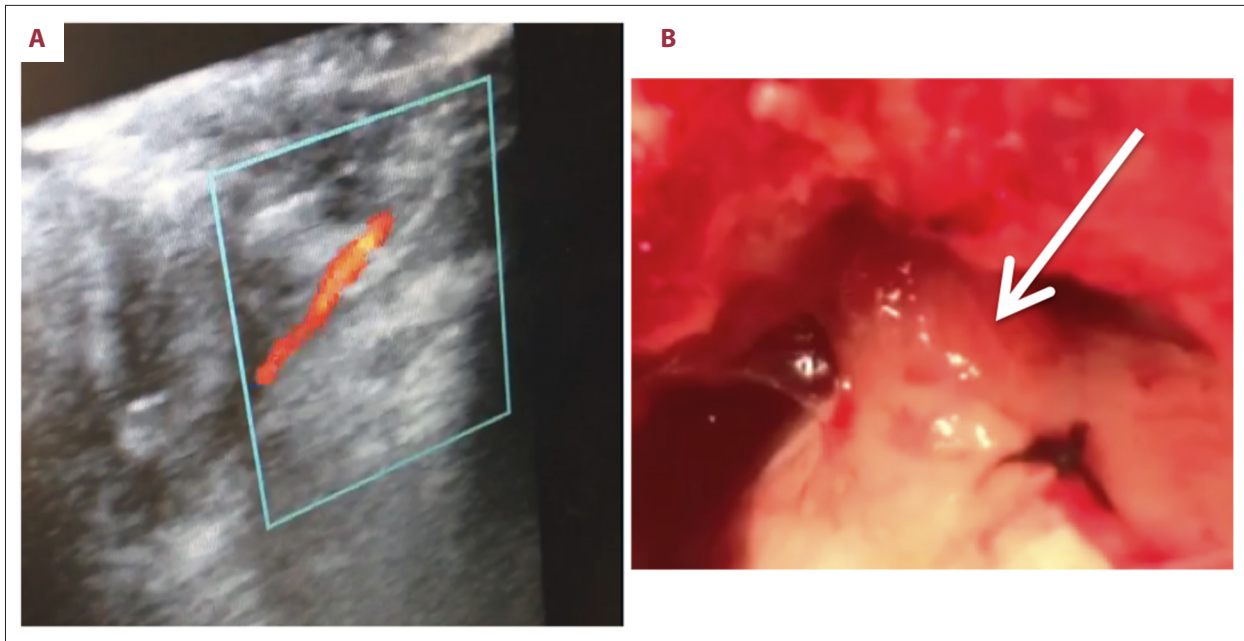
Pial syngangiosis during washout showing viable collateral vessels on the left side. (A) Ultrasound of pial syngangiosis during washout showing viable collateral vessels on the left side. (B) Photographic image of the intraoperative pial syngangiosis on the left side during washout. The arrow indicates the vessel.
